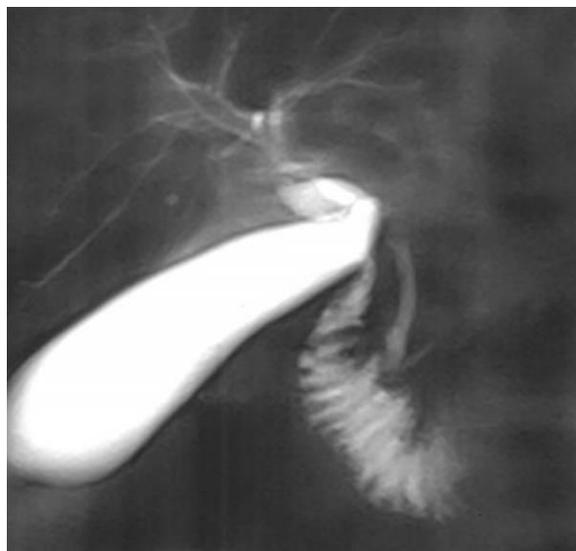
MRI cholangiography with paramagnetic MDC with biliary excretion. One hour after the start of the iv infusion, the MDC is significantly concentrated in the gallbladder and biliary tract causing hyperintensity in T1-weighted sequences.
